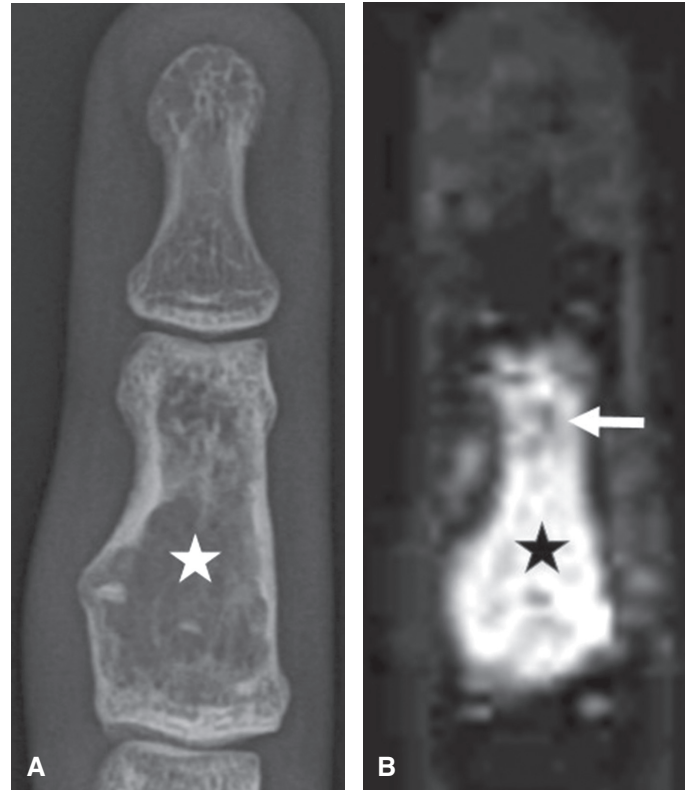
Enchondroma. *A:* PA radiograph of the ring finger shows an expansile lytic lesion (*star*) concentrically located within the middle phalanx. *B:* Coronal, T2-weighted, fat-saturated MR image shows a corresponding T2 hyperintense lesion (*star*), which is confined within the bony cortex. There are internal regions of T2 dark chondroid matrix (*arrow*).
